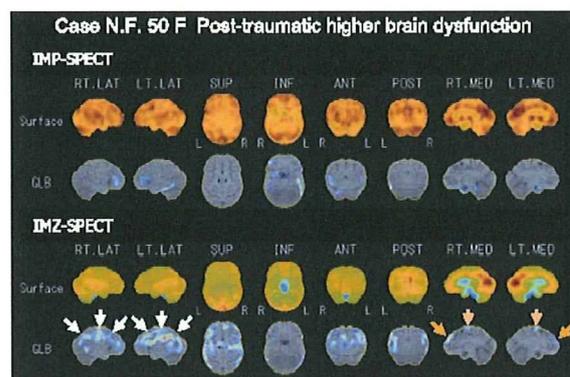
脳外傷後高次脳機能障害例のSPECT画像解析
